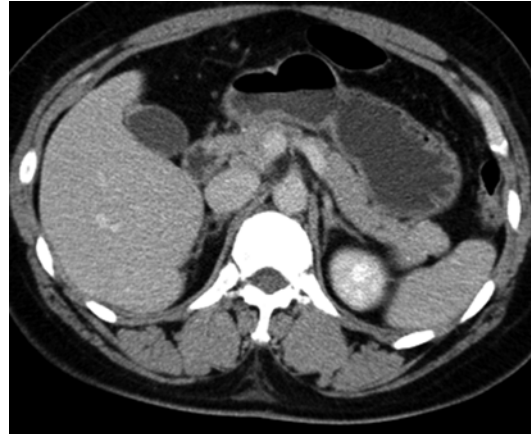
An isodense lesion at the tail of the pancreas was identified. It was difficult to identify the lesion without information from a CT scan in arterial phase
